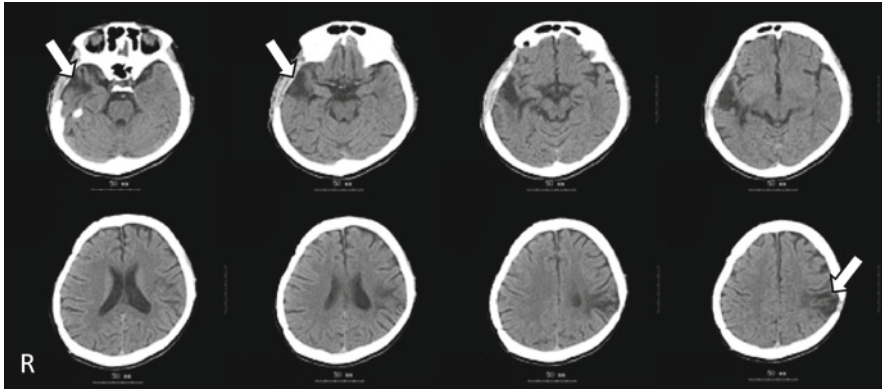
Computed tomography (CT) findings of case SA
